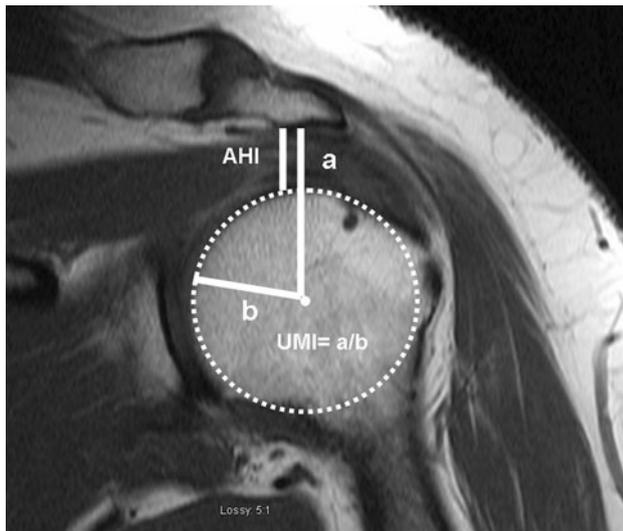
The UMI is calculated on MRI of the shoulder by dividing the distance between the lowest point on the acromion to the center of the humeral head (a) with the radius of the humeral head (b).
